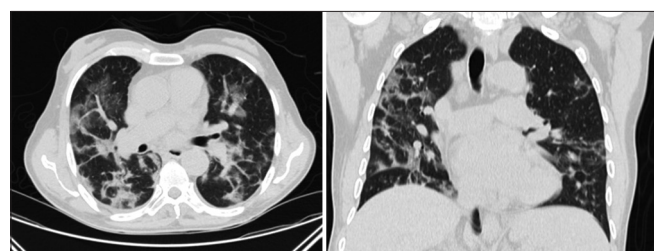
The chest computed tomography revealed ground-glass opacity in both lungs
